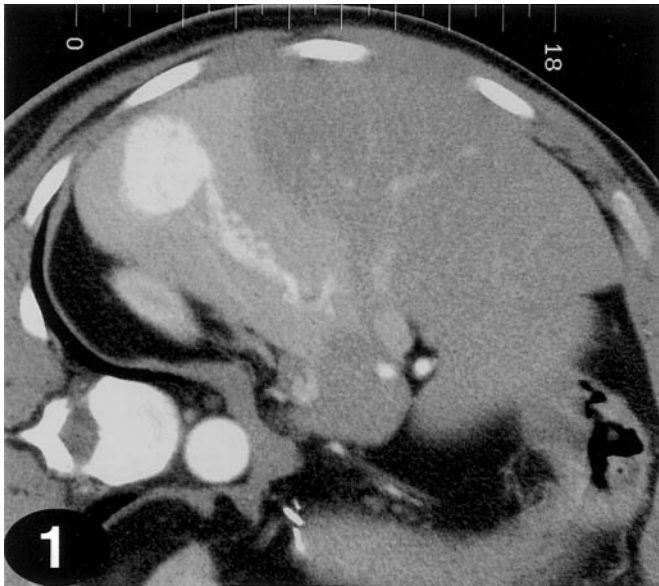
Arterial-phase helical computed tomographic scan showing a prominent feeding vessel arising from the right hepatic artery and a 3.5-cm hypervascular mass.
